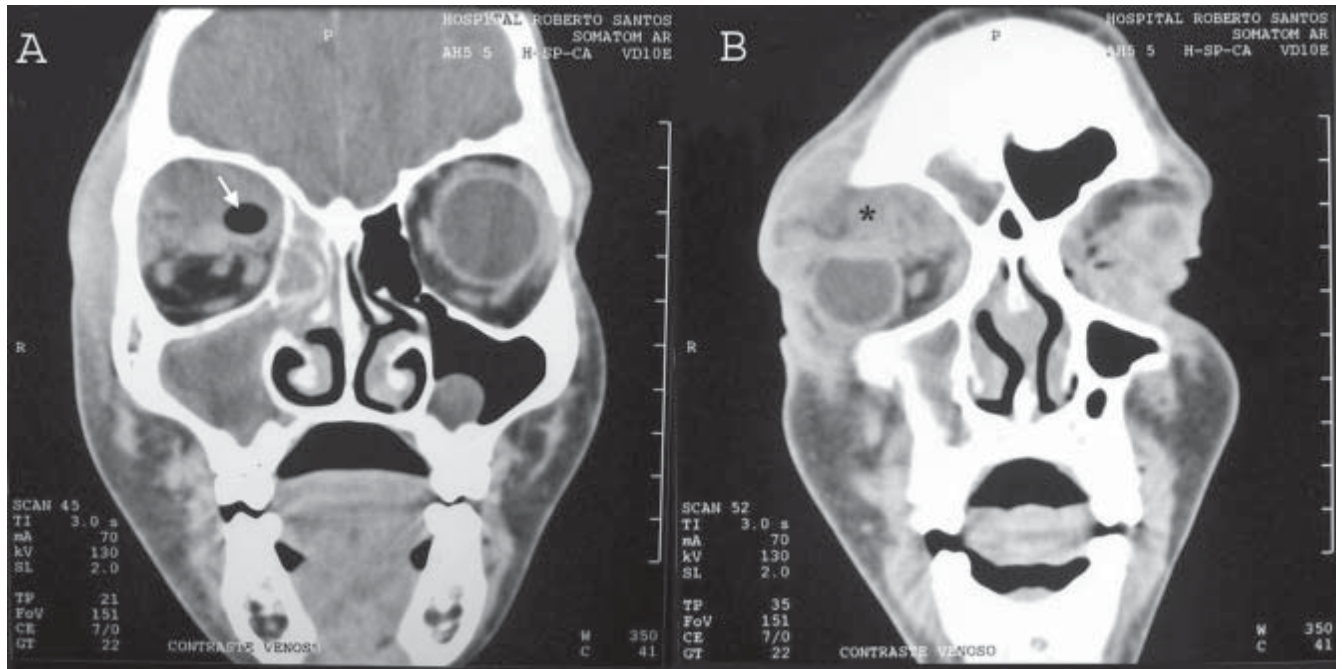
Computed tomography. Coronal section. Emphisema (arrow) inside the orbit and the sinusitis at maillary sinus and ethimoidal cells (A). The right side of the sphenoidal sinus mucosa was inflamed (arrow) (B). Purulent collection (*) was compressing the ocular globe (B). No evidence of orbital roof fenestration or brain inflammation
